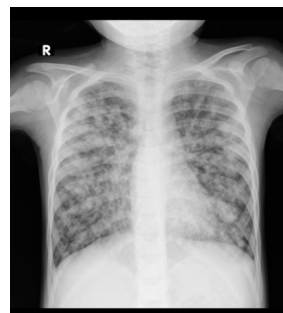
Chest X-ray (day 10))
